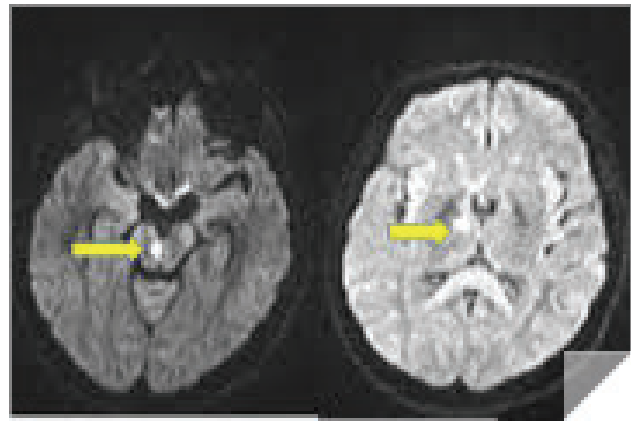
Diffusion-weighted imaging (DWI) sequence showing a restricted diffusion in the right mesencephalic (picture left) and the right thalamic region (picture right) which confirms ischaemic process.
